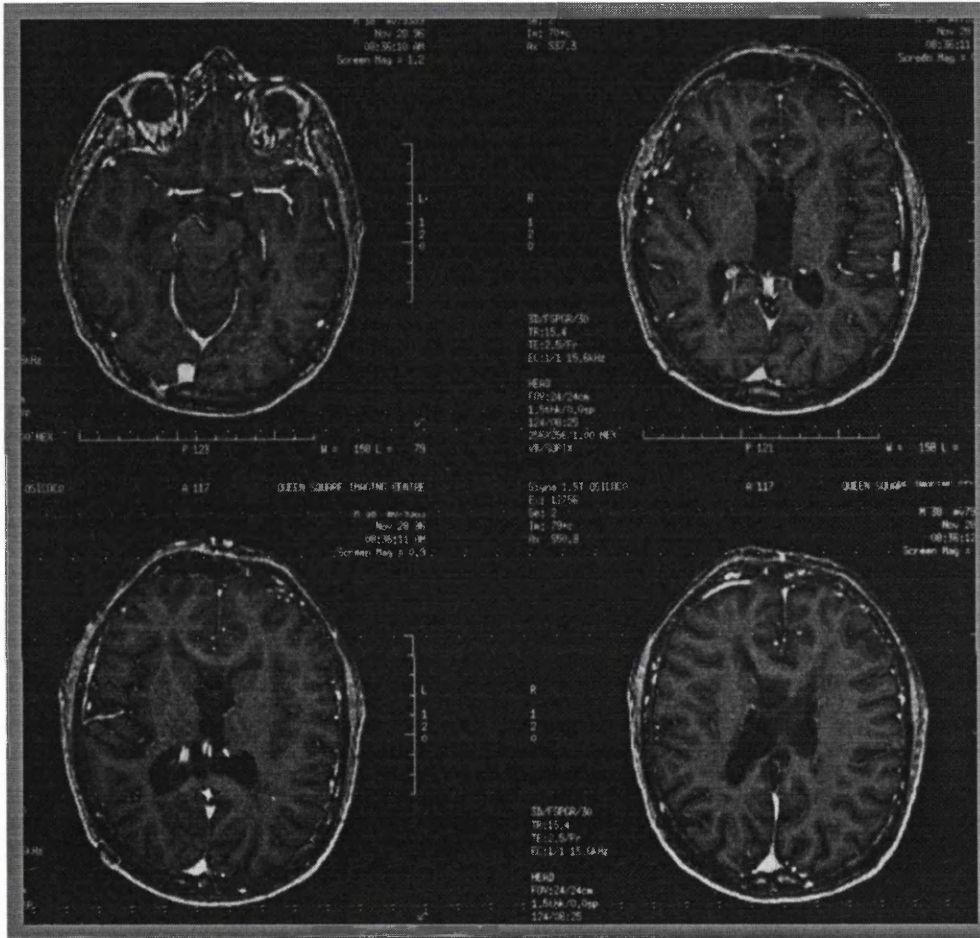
Axial MR images of IGN case 1. The dilated third ventricle, wide occipital horns and narrowed anterior horns are shown. Thus, the potential difficulties of freehand endoscope insertion and operation can be appreciated.
